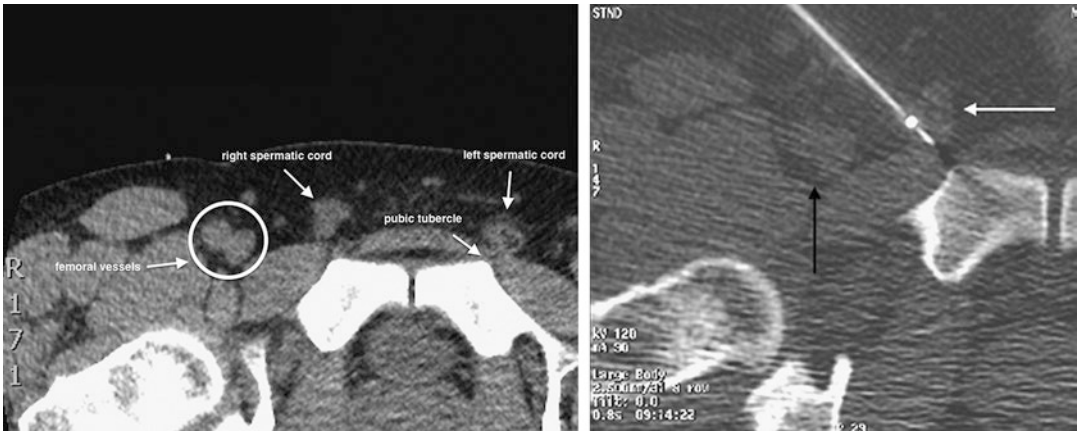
CT images showing the spermatic cord in relation to the pubic tubercle and femoral vessels. *White arrow* on right image is needle tip placement posterior and lateral to spermatic cord. *Black arrow* is femoral vessels
